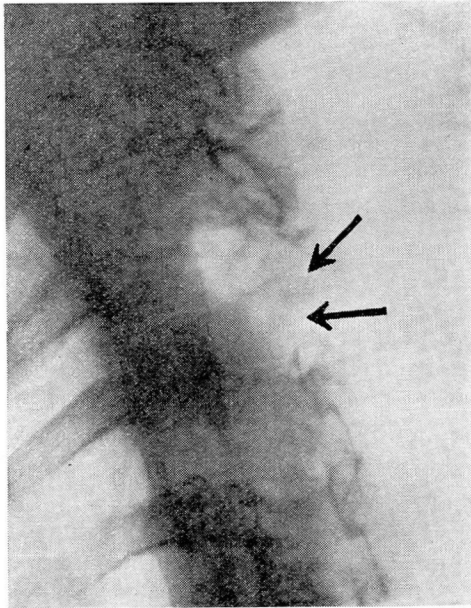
Lateral roentgenogram of spine showing erosion of spinous process and laminae of the fourth thoracic vertebra by plasma cell myeloma.
